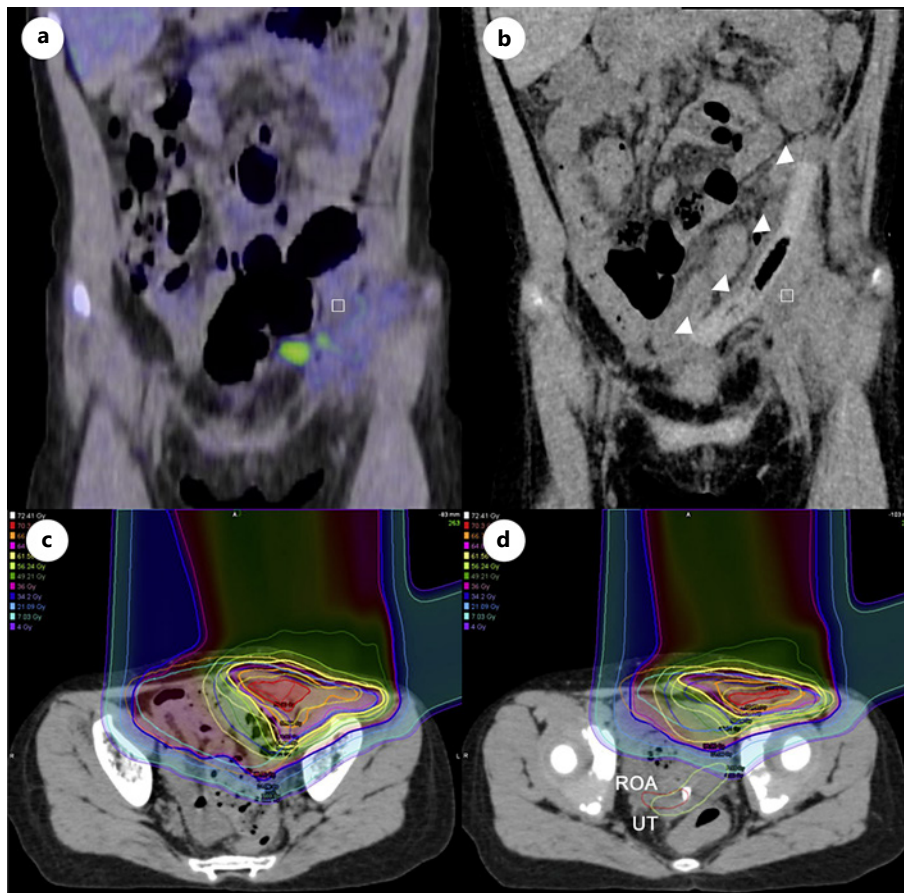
a Pre-SSP-operative PET-CT. FDG uptake around the cystic lesion in contact with the left iliac muscle. b CT on the 3rd day after the SSP operation. The intestinal tract, UT, and ROA were away from the irradiation field. c, d Dose distribution map of PBT delivered using pencil beam scanning for the residual lesion of pelvic MPNST. □, cystic lesion; Δ, absorbable spacer (NESKEEP); UT, uterus; ROA, right ovarian appendage; PET-CT, positron emission tomography-computed tomography.
